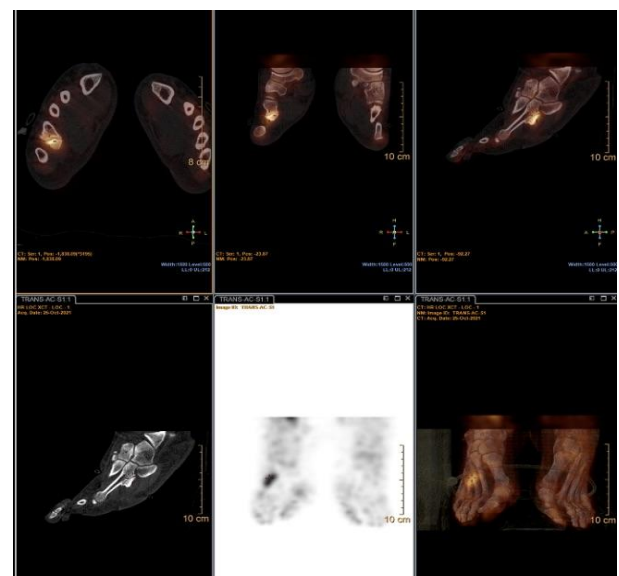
3D reconstruction CT-scan and SPECT-CT.
